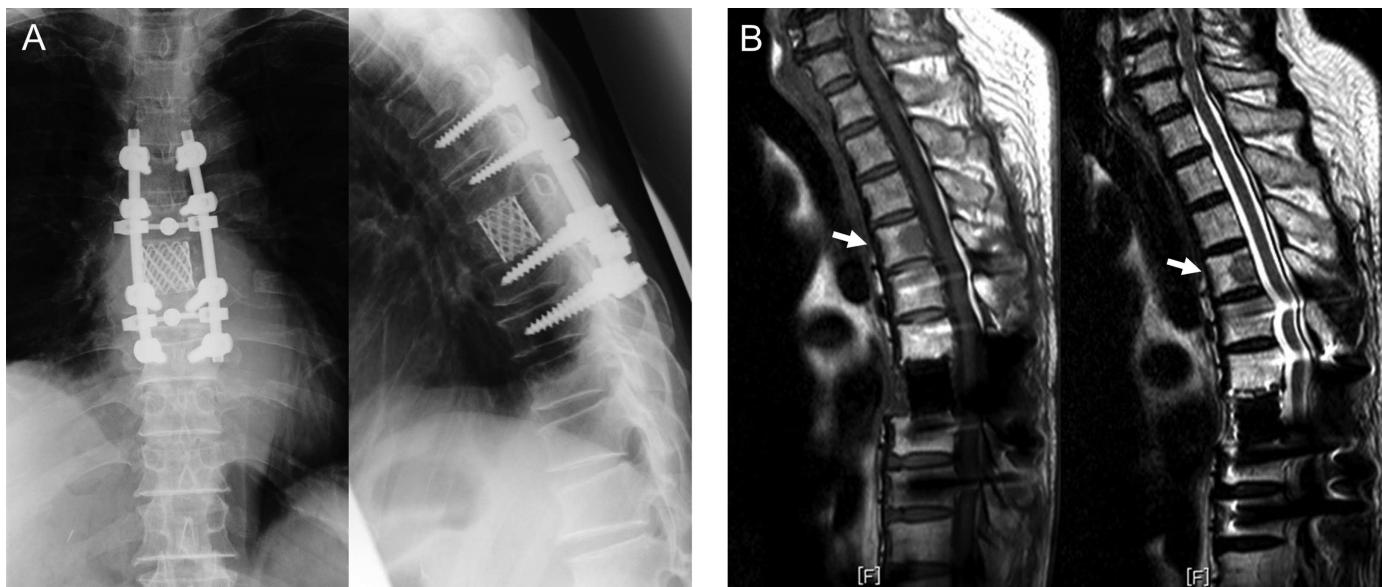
(A) Anteroposterior view (left) and lateral view (right) of radiographs 2 wk after total *en bloc* spondylectomy for T7 metastasis. (B) Sagittal views of the T1-weighted (left) and T2-weighted (right) magnetic resonance images at 3 mo after surgery. Arrows indicate the newly developed metastasis at T4.
